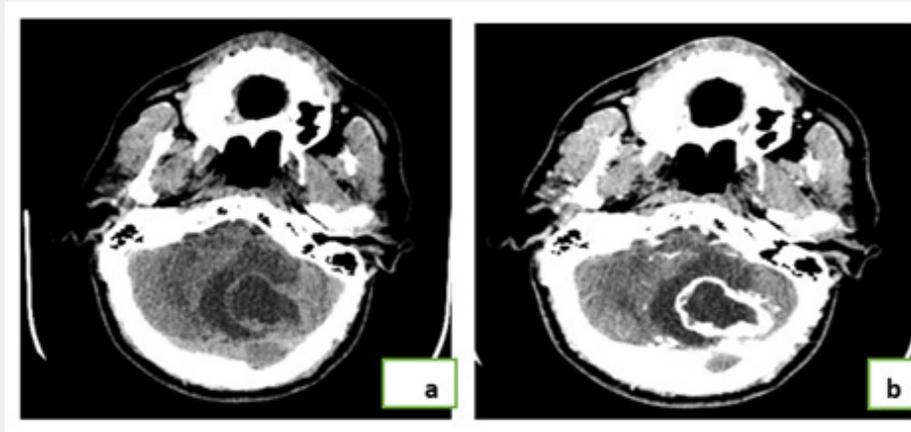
Cerebral CT scan before injection (a) and apéro injection of PDC (b, c) objectifying a volu-minous tumor process with a dual fluid component, which riphérique was modified after contrast and an ecrotic tissue component with central liquefaction and a fleshy peripheric tissue that enhances in intense-handled manner safter injection of PDC as part of von Hippel Lindau disease.
